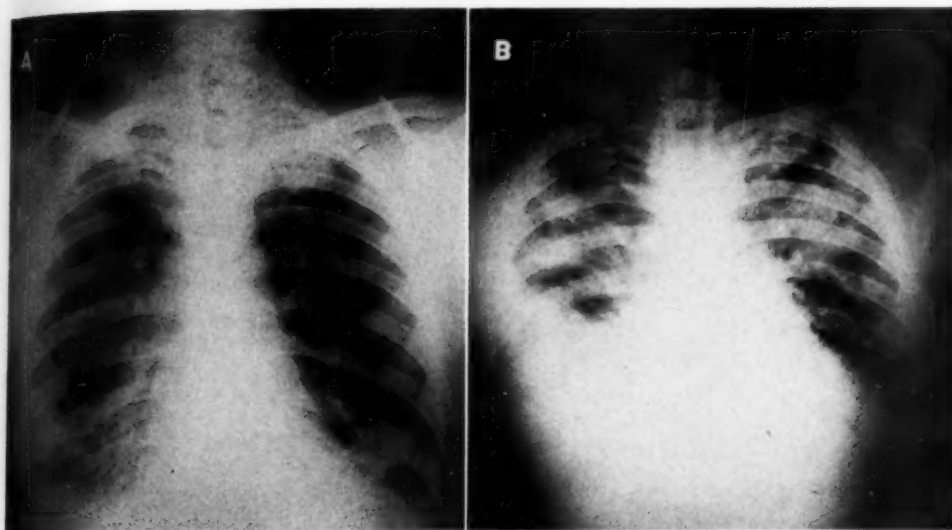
A. Roentgenogram made eighteen days before death. Compared with the appearance in Fig. 1 there has been peripheral migration of the density in the right lower lung field. A shadow has appeared in the left apex with a questionable rarefied center, found at autopsy to be an alveolar carcinoma with central cavitation. B. Roentgenogram made one day before death, showing bilateral pleural effusion with extensive parenchymal changes, found at autopsy to be due to edema and radiation reaction. The tumor in the left apex has enlarged.
